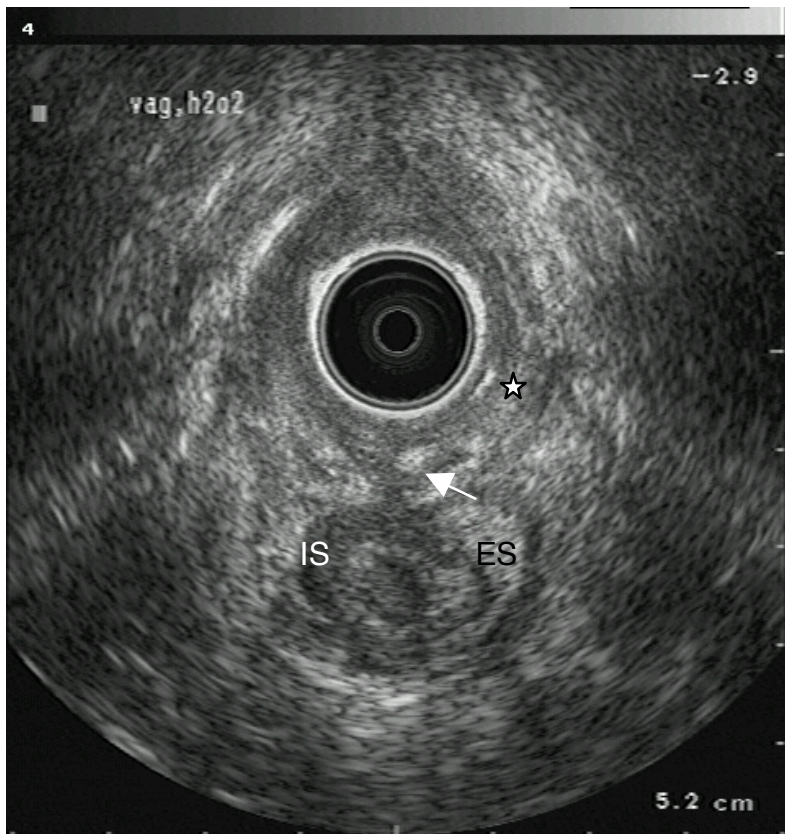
Transvaginal ultrasonography with hydrogen peroxide infused via the fistula opening in the introitus (astriks) showing a transsphincteric anovaginal fistula (arrow) in patient 3. IS internal sphincter; ES external sphincter
